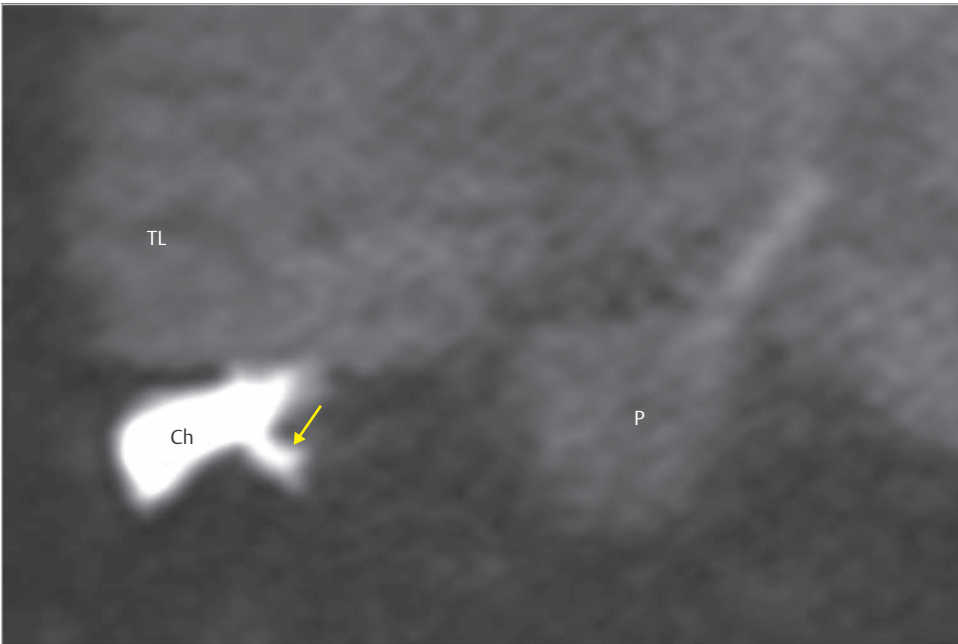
A very high signal intensity in the coronal section of diffusion-weighted MRI corresponds to cholesteatoma. A small protrusion indicates descending of cholesteatoma to the posterior mesotympanum (arrow). Ch, cholesteatoma; P, pons; TL, temporal lobe.
